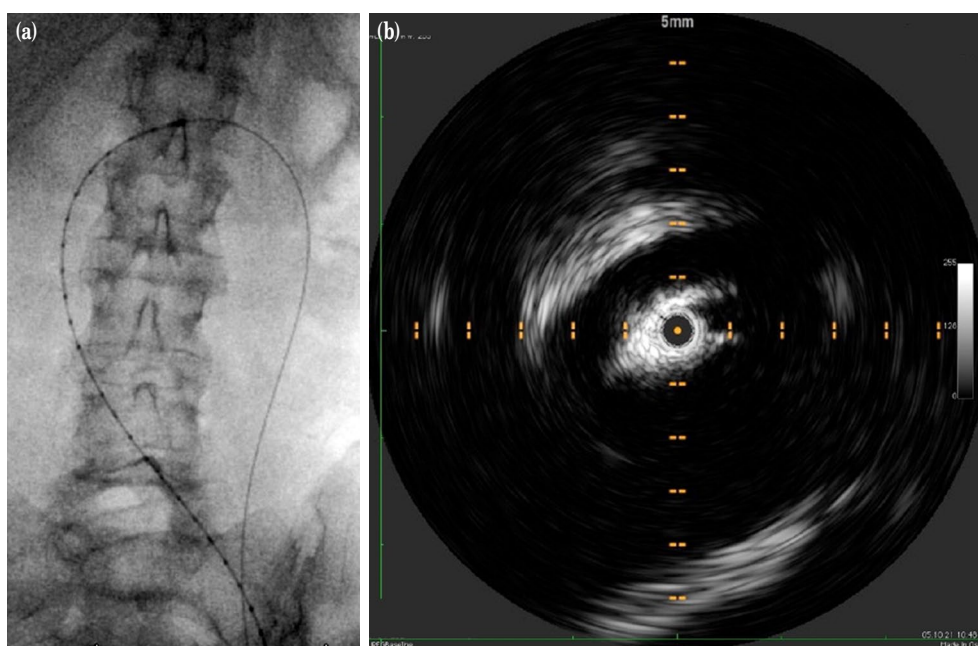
Location of Nutcracker on (a) fluoroscopy and (b) intravascular ultrasound (IVUS).
